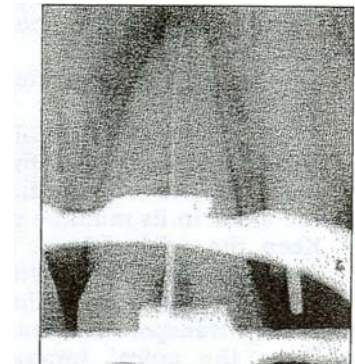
The No. 10 instrument slips, slides, then finally reaches the PDL at the radiographic terminus of the maxillary central incisor.
